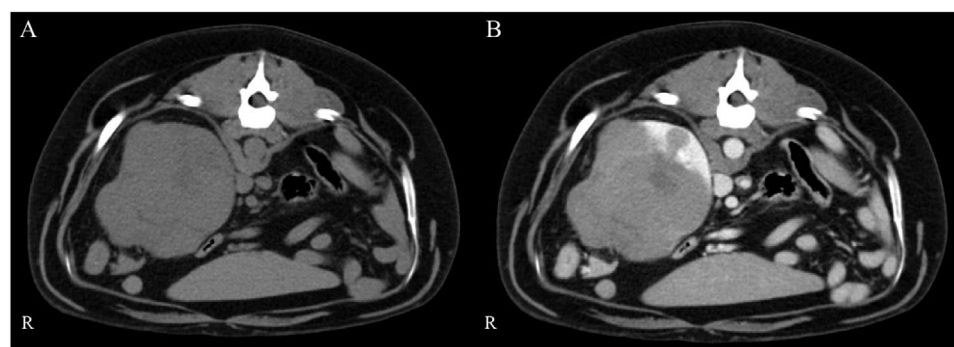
Computed tomographic images. Transverse views before (A) and after contrast administration (B) where an enlarged mass on the cranial pole of the right kidney was seen. The mass was isoattenuating compare to the kidney in the pre-contrast phase with homogeneous enhancement in the post-contrast phases, being hypoattenuating to the normal renal parenchyma
